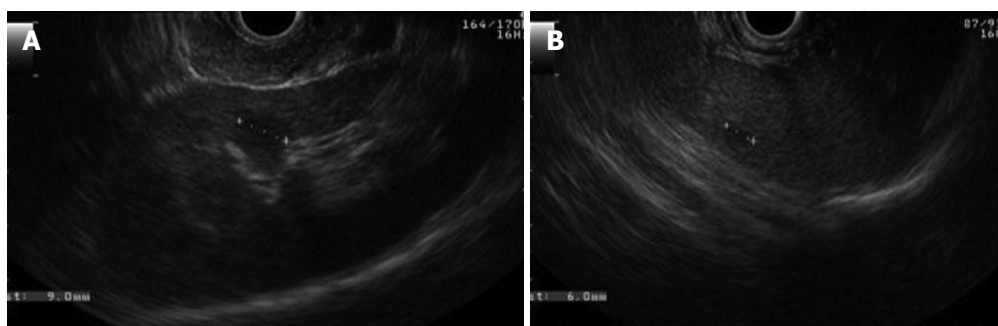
Endosonography. A: A cyst in the renal cortex; B: A cyst in the spleen.
